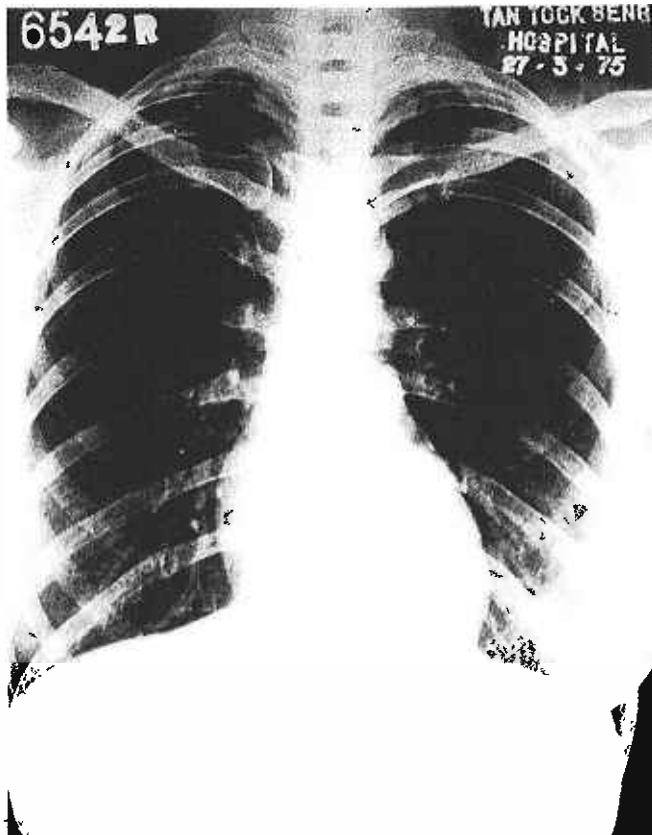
Chest radiograph taken in March 1975 shows bilateral reticulonodular opacities.
